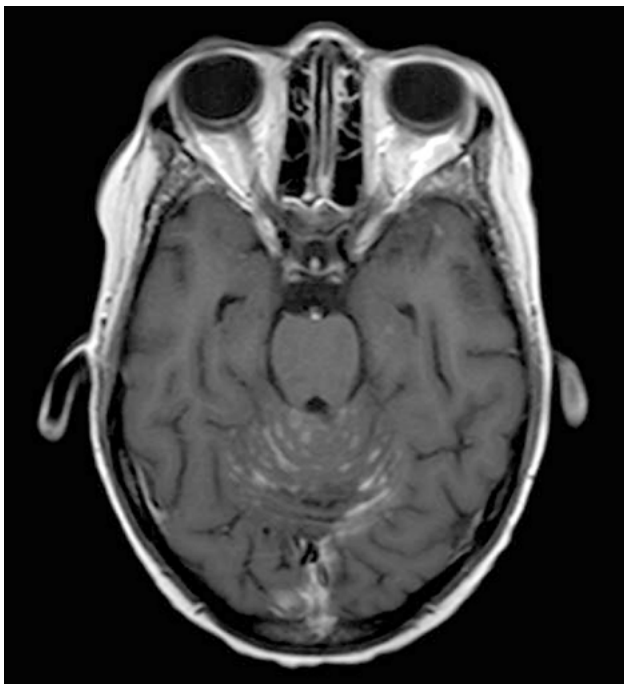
Leptomeningeal sulcal enhancement at the cranial level on axial T1-weighted, gadolinium-enhanced magnetic resonance imaging of the brain.
